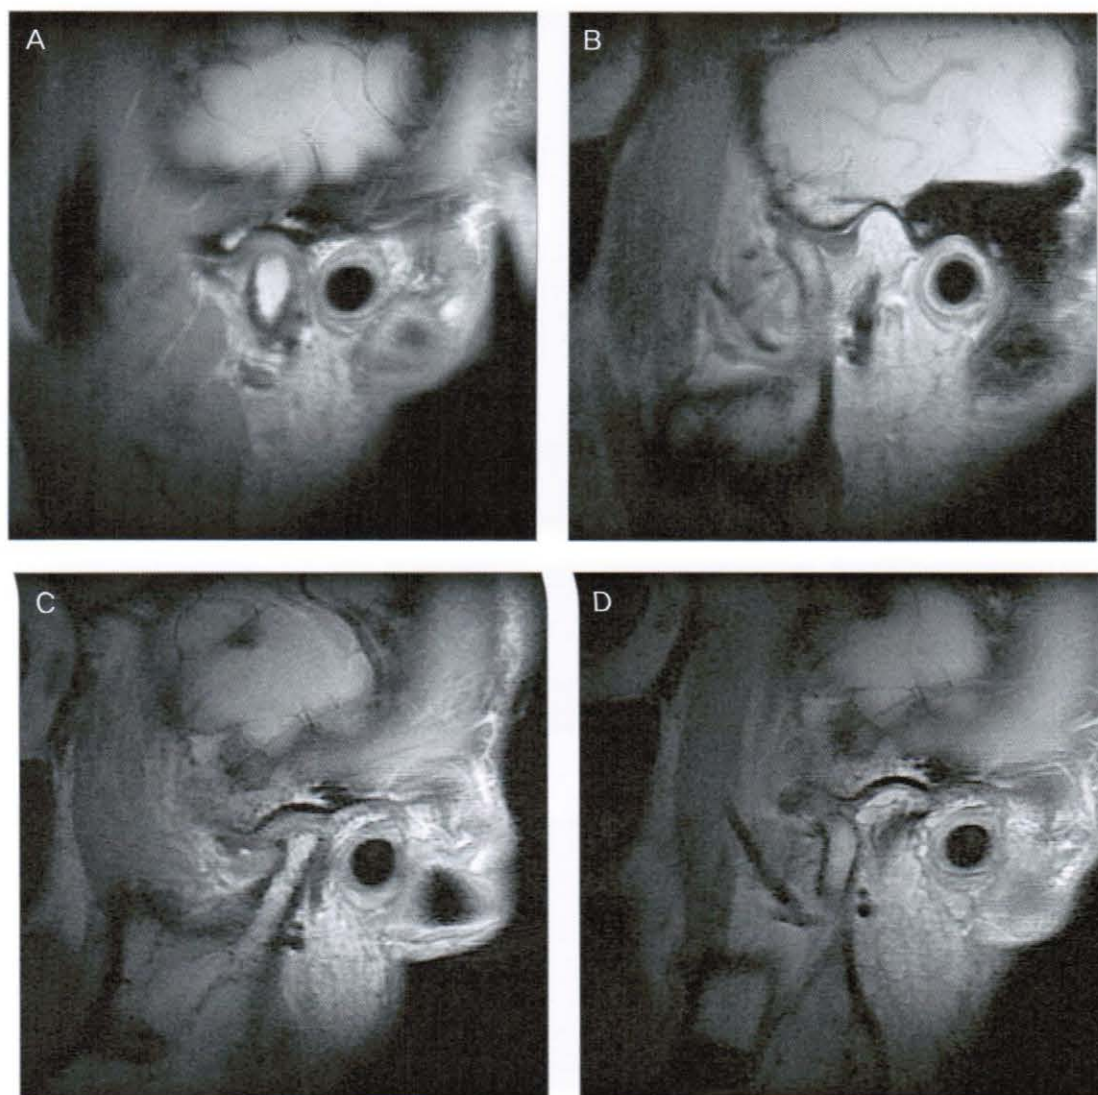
Pre-treatment MRI of the TMJ
